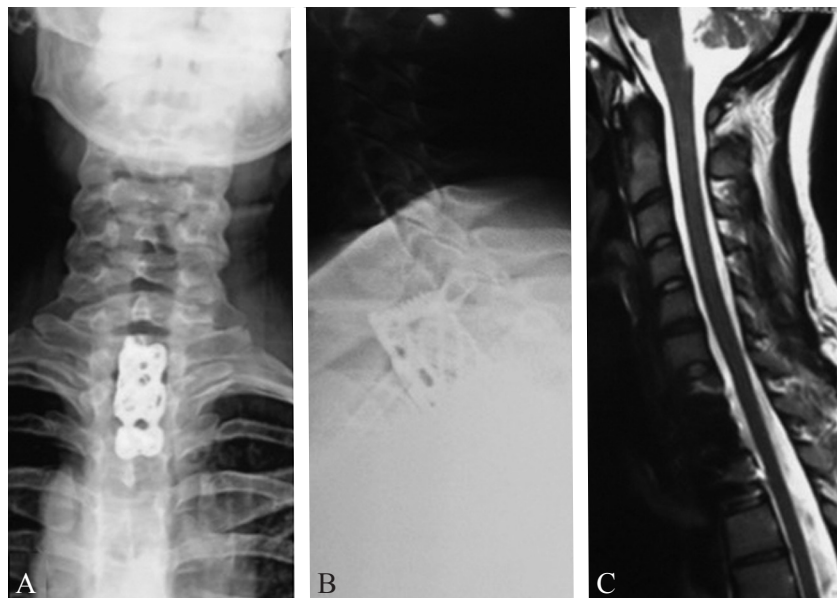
Postoperative radiological studies: A, B) postoperative X-ray; C) postoperative sagittal T2W MRI shows the titanium mesh implant and anterior plate fixation.
